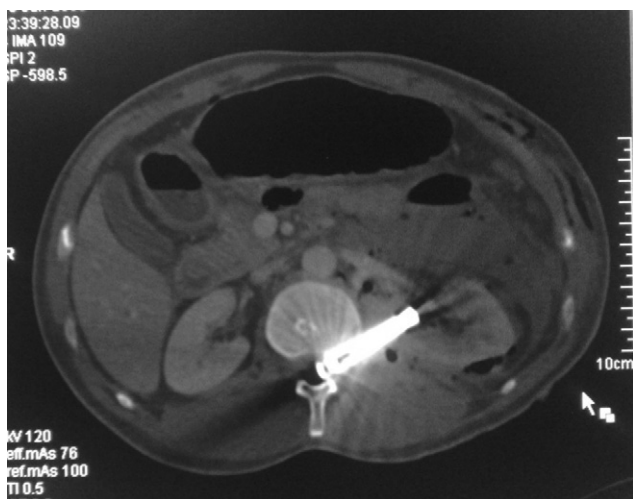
Axial view of plain CT-scan of upper lumbar spine shows metallic-bullet (approx 60 mm long) embedded in spinal canal and pedicle of vertebra in a paraplegic patient.
